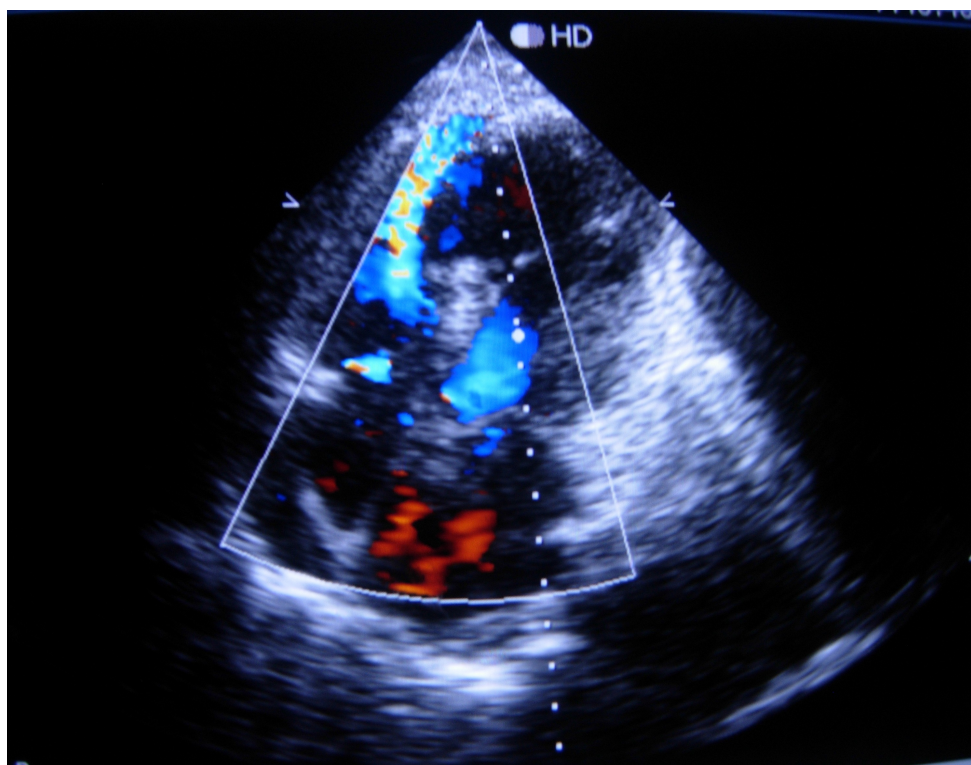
Echocardiography showing Apical VSR in a patient with AWMi
